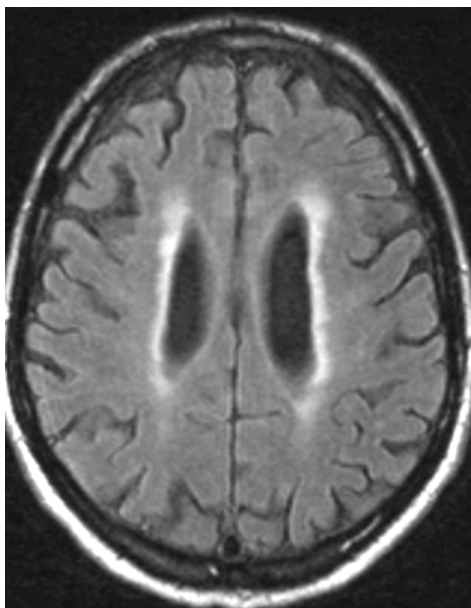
MRI brain images, obtained in the axial plane with a "FLAIR" sequence. Images showing different types of white matter lesions: 1) Small "caps" adjacent to the frontal horns, 2) More pronounced "caps" next to the frontal and posterior horns, 3) Periventricular bands, 4) Pronounced periventricular bands extending into the deep white matter, 5) Punctuate WMC in the deep white matter, 6 and 7) Punctuate and patchy WMC in the deep white matter, with sparing of the subcortical U-fibres, 8) Confluent WMC engaging most of the white matter in the frontal and parietal lobes, with sparing of the subcortical U-fibres.
